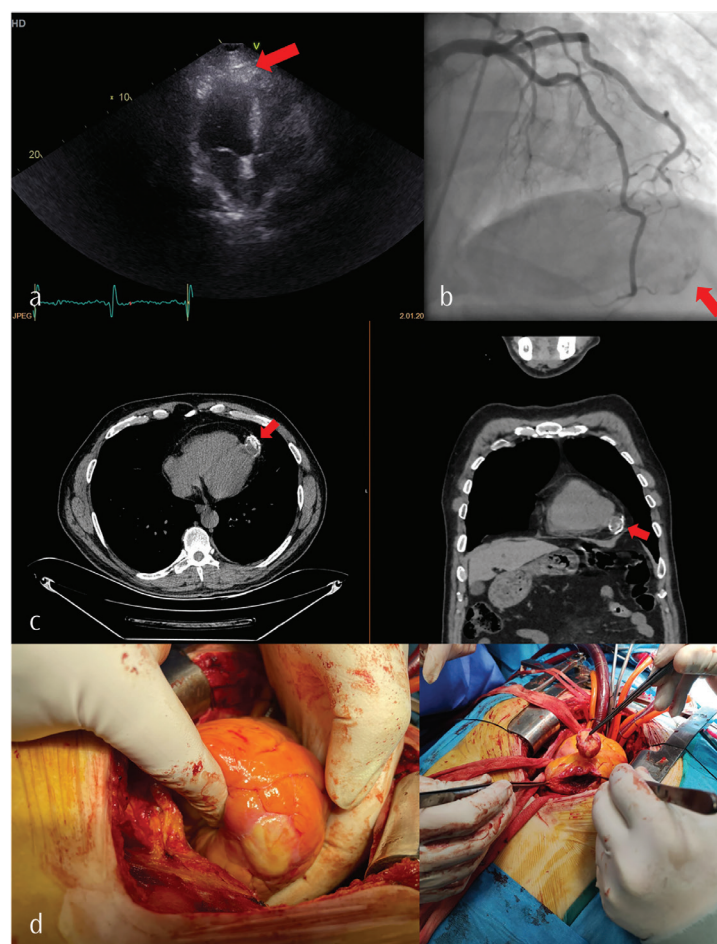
(a) Apical 4-chamber view on initial echocardiographic evaluation. (b) Calcification noted at the apex of the left ventricle on angiographic imaging. (c) Calcified hypodense lesion on computed tomography consistent with cardiac hydatid cyst. (d) An intramyocardial lesion approximately 4 cm in diameter in the apical region of the left ventricle localized lesion was seen, and the lesion was excised.
